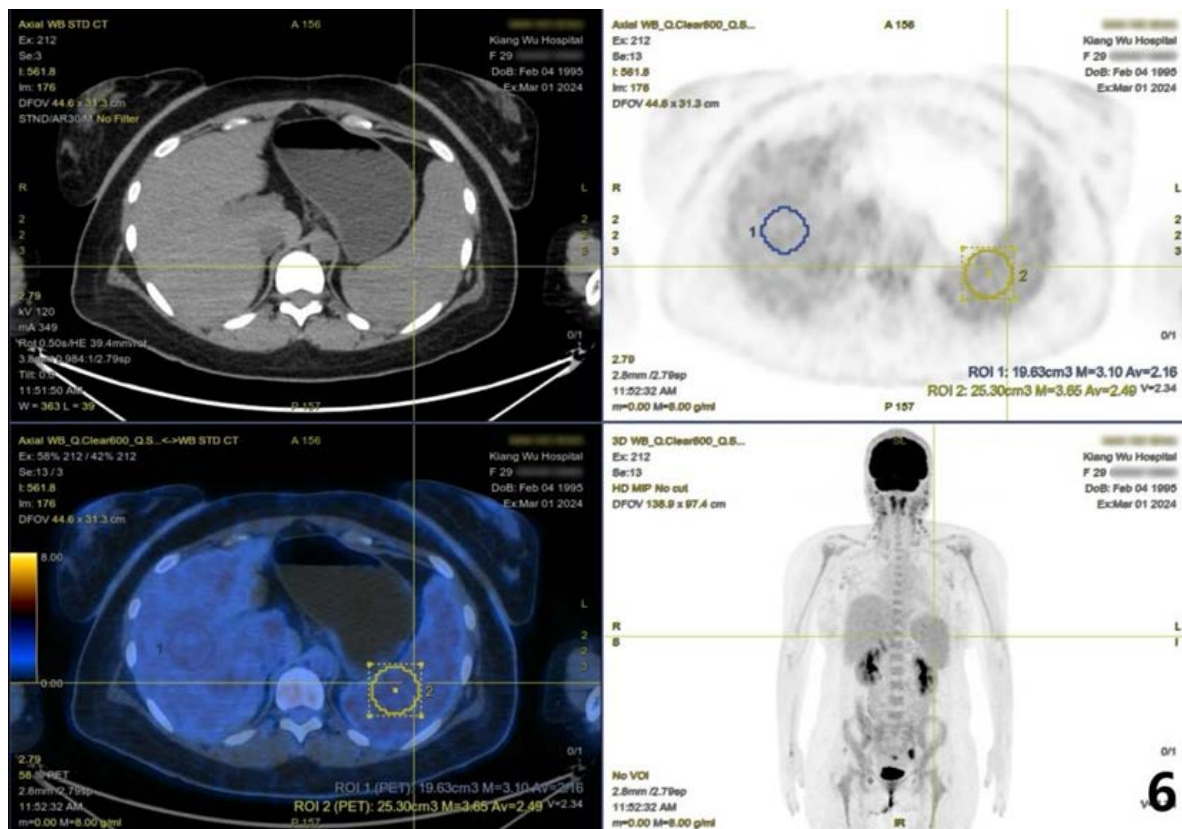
A 29-year-old woman with BPDCN underwent an 18F-FDG PET/CT examination. The spleen demonstrated an SUVmax of 3.7, which was slightly higher than the liver's SUVmax of 3.1.
